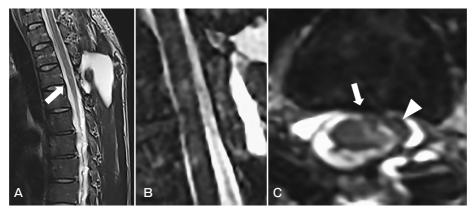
Postoperative MR images. A, A sagittal T2-weighted image revealed the cerebrospinal fluid space ventral to the spinal cord at the Th3/4 level (arrow); B, On a sagittal CISS image, the ventral deviation of the spinal cord was shown to be reduced; C, An axial CISS image showed the release of the herniated spinal cord. A mildly hyperintense lesion (arrow) could be observed on the left side of the spinal cord. A low-signal band-like structure (arrowhead), which corresponded to the inserted DuraGen[®] pieces, could be seen on the outside of the inner dura mater.
